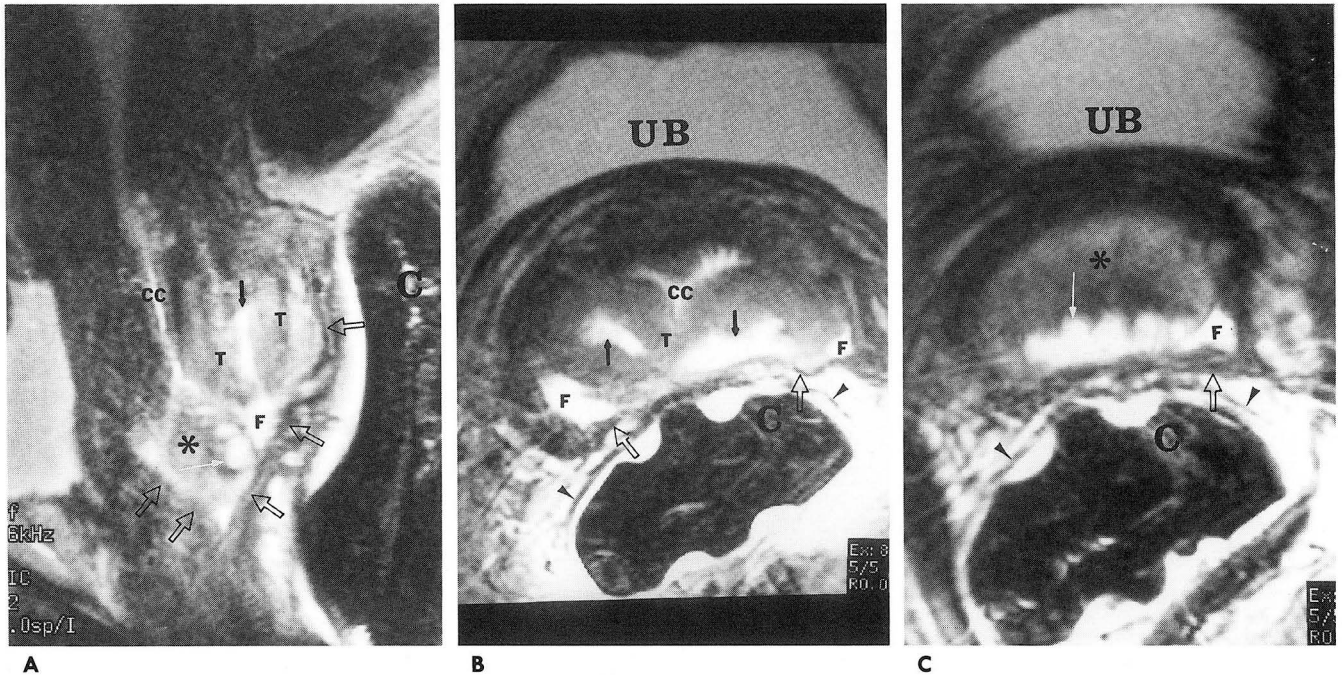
In vivo MR images of 41-year old woman with stage-Ib cervical carcinoma.
